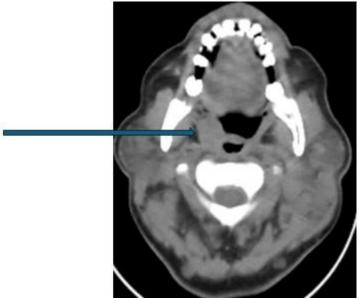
Axial CT of a right palatine tonsil tumor
